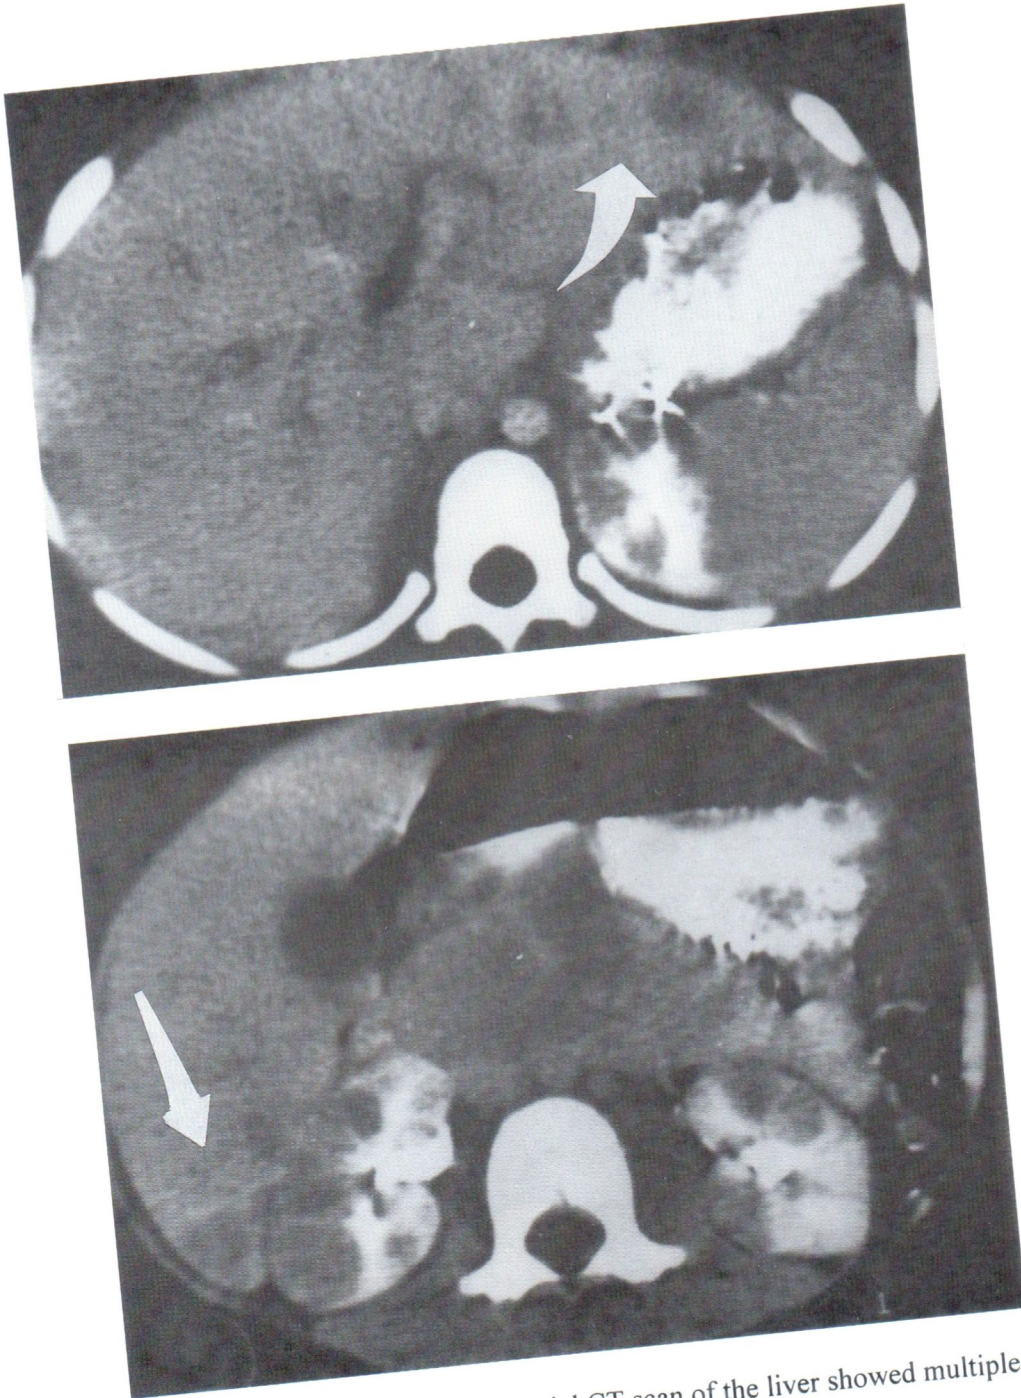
I.V. contrast enhanced axial CT scan of the liver showed multiple low density leukemic nodules.
